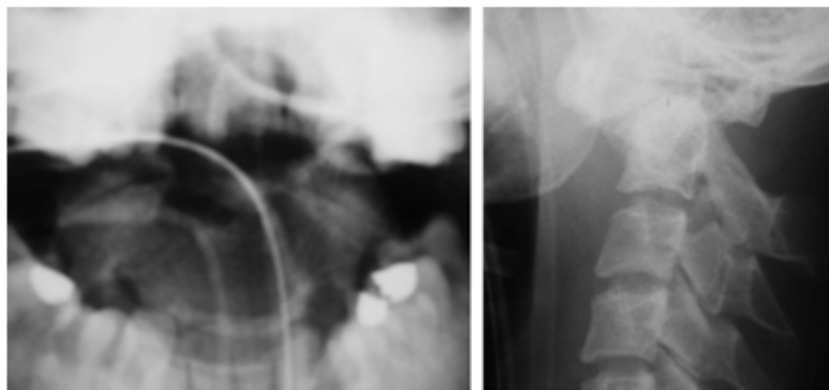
On the radiographs, the ossicle has smooth cortical margins and is separated from the base of odontoid process.
